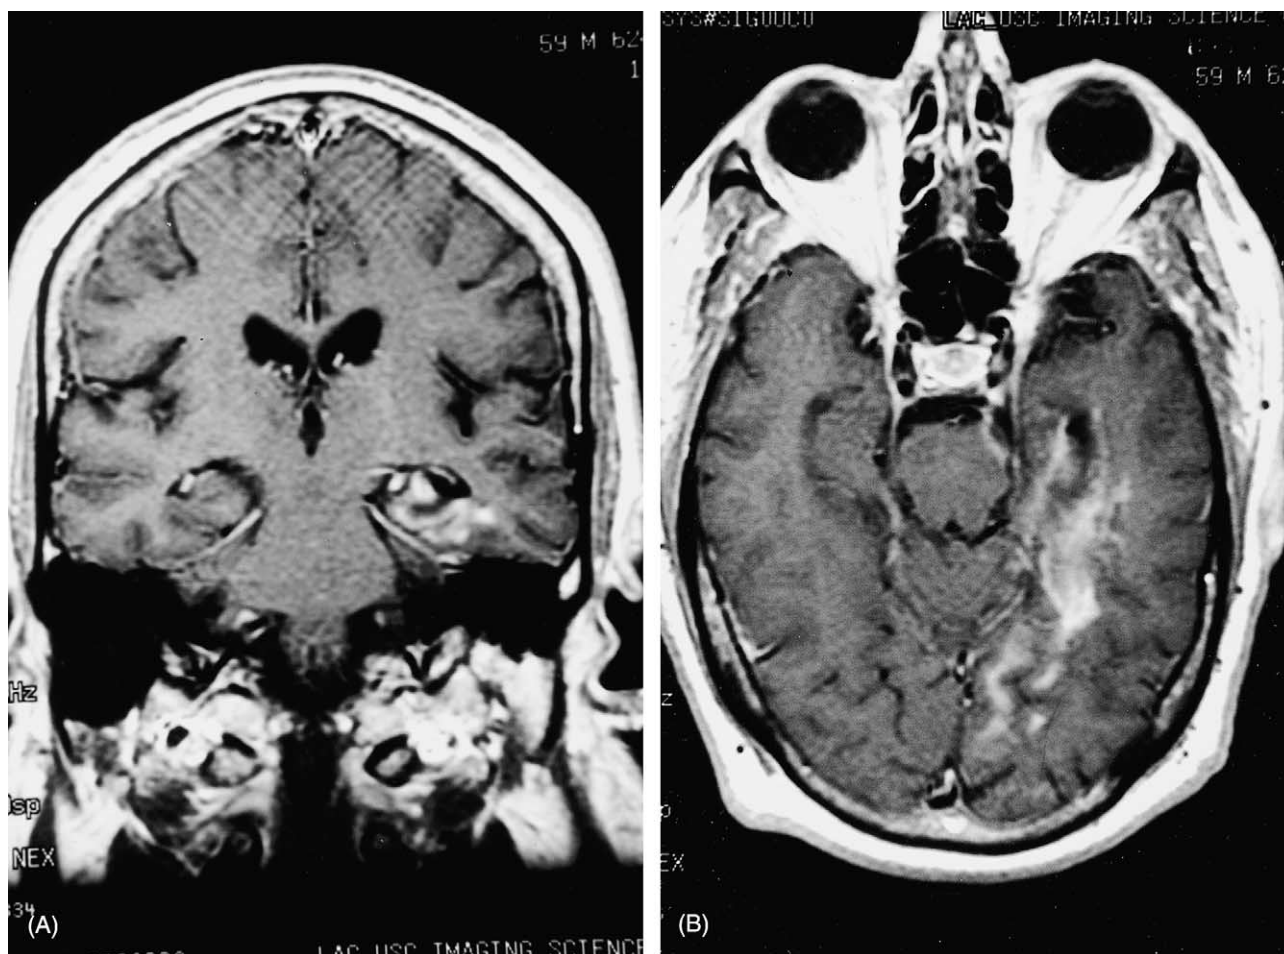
(A) and (B) Coronal and sagittal cranial MRI images demonstrating an infarct extending from the left temporal lobe including the hippocampal complex to the occipital lobe in the distribution of the left posterior cerebral artery.
